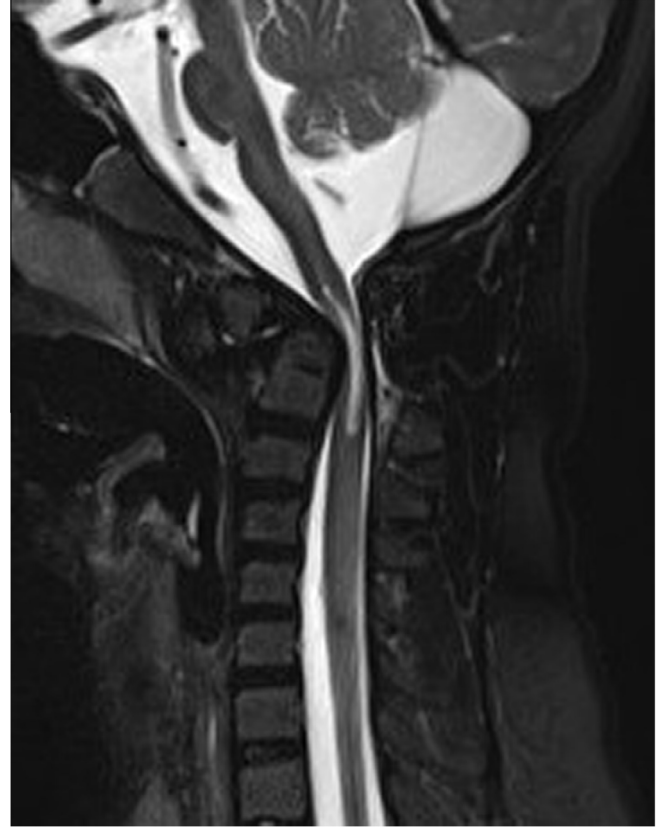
Sagittal spinal T2-weighted MRI reveals marked narrowing of the underlying thecal sac and impingement of the cervicomedullary junction by severe anterior displacement of C1 and the tip of C2 in front of the base of the odontoid.
